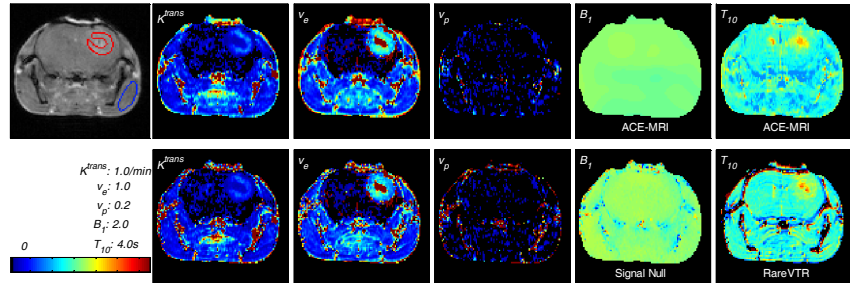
Comparison between ACE-MRI (1st row) and DCE-MRI (2nd row) estimated pharmacokinetic parameters, ACE-MRI estimated T_{10}/B_1 maps and T_{10}/B_1 maps from separate signal null method and RareVTR method measurements.
